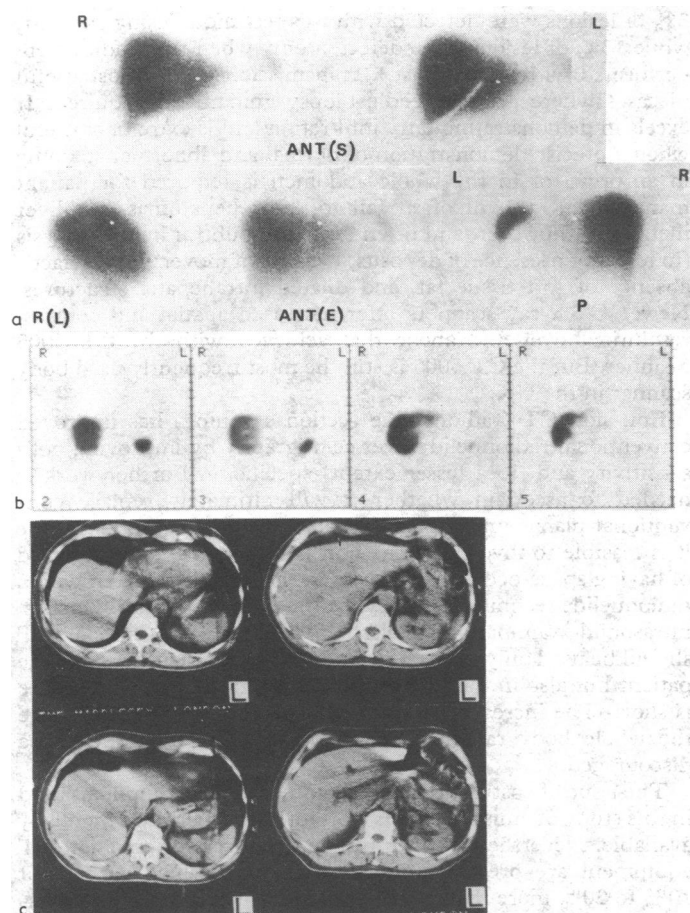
Images from all three techniques of the liver of 59-year-old woman with non-Hodgkin's lymphoma: (a) normal five-view planar gamma-camera study of the liver; (b) normal transaxial sections by emission CT; (c) normal transaxial sections by transmission CT.
